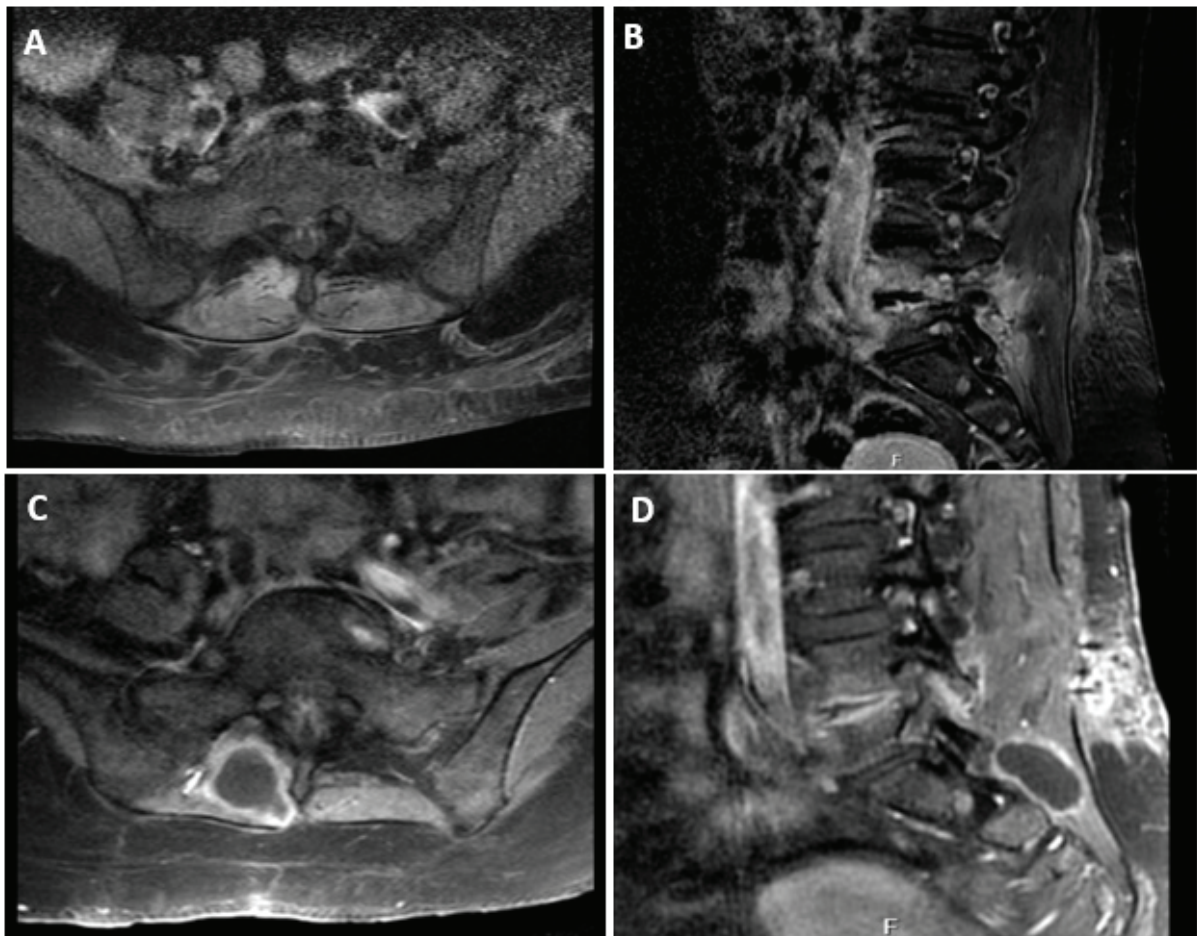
(A, B, C, D): Axial and sagittal T1-weighted with contrast sections of magnetic resonance imaging (MRI) are the after fifth operative early view. The axial and sagittal T1-weighted images with contrast enhancement showed a posterior paravertebral mass with a peripheral rim in the last MRI.
